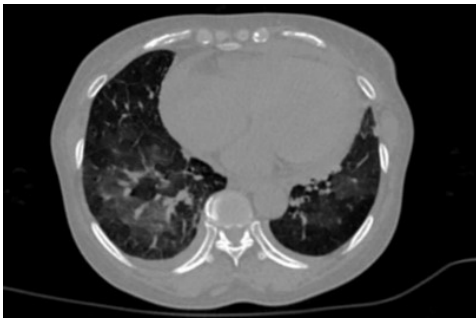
A cross-sectional CT image of a human chest
